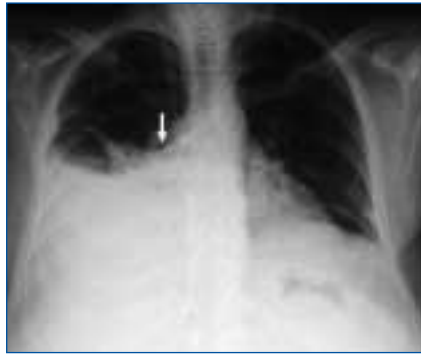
Chest X-ray showing right pleural effusion due to impaction of the left jugular catheter within the pleural space.
